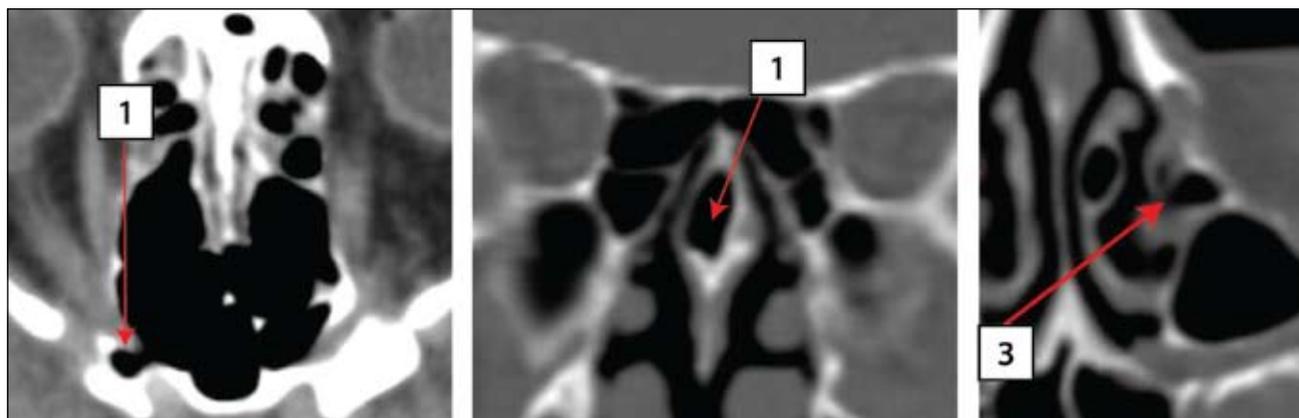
Crano-facial CT scan, bone window, axial slice: 1. hyperpneumatization of the right Agger nasi; 2. bilateral bilocular pneumatization of the middle turbinate (two cells); 3. pneumatization of the right superior turbinate; 4. right Onodi cell; 5. pneumatization of the right supreme turbinate; 6. hyperpneumatization of the sphenoid sinus, with no intersinusal septum; 7. pneumatization of the left superior turbinate
